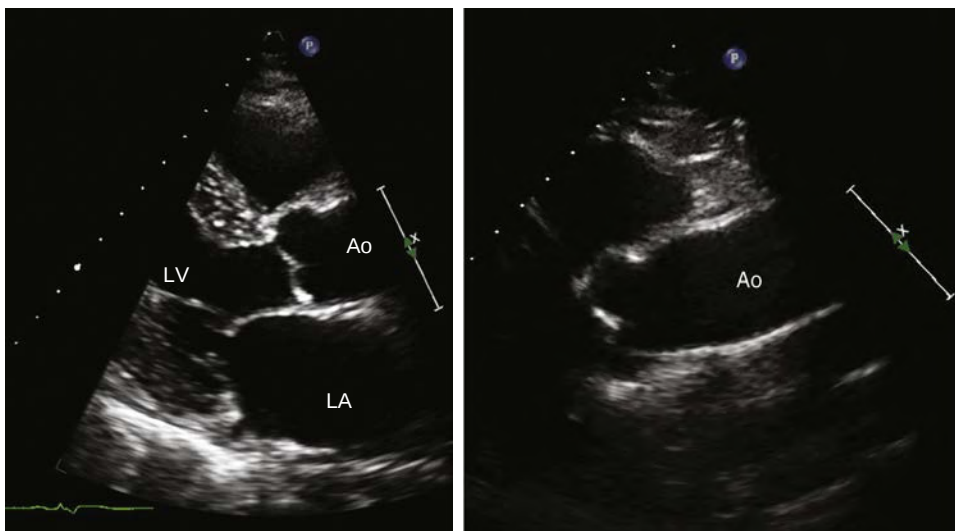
Ascending aorta. The ascending aorta is visualized by moving the transducer up an interspace from the parasternal long-axis view. Ao, Aorta.
